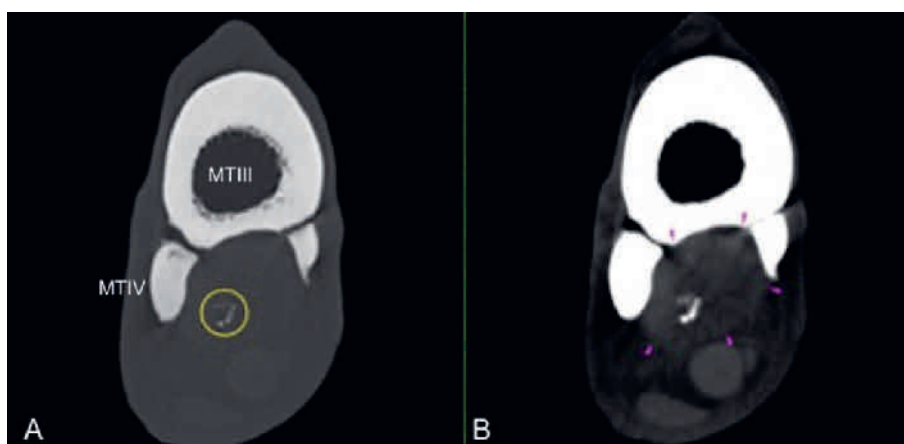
Transverse CT images on a bone (A) and soft tissue algorithm (B) approx. 6 cm distal to the TMTJ. Yellow circle indicates mineralization of the PSL, which is markedly enlarged (purple arrowheads). | Transversale CT-Bilder in Knochen- (A) und Weichteil-Algorithmus (B) ca. 6 cm distal des Tarsometatarsalgelenks. Der gelbe Kreis zeigt die Mineralisierung des proximalen Fesselträgers, der deutlich vergrößert ist (lila Pfeile).
